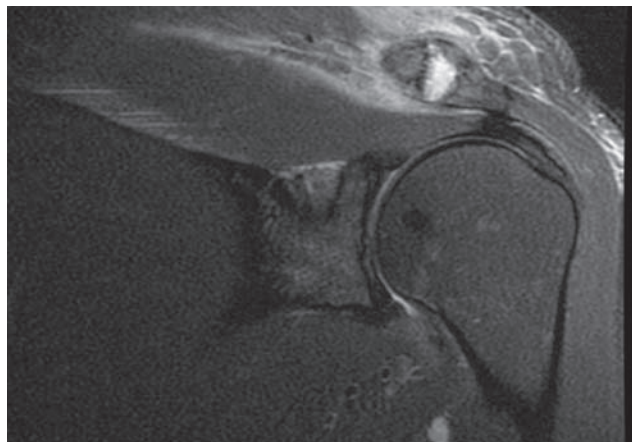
Coronal magnetic resonance imaging shows increased signal uptake in acromioclavicular joint and surrounding soft tissue with bony edema of distal clavicle and acromion.
